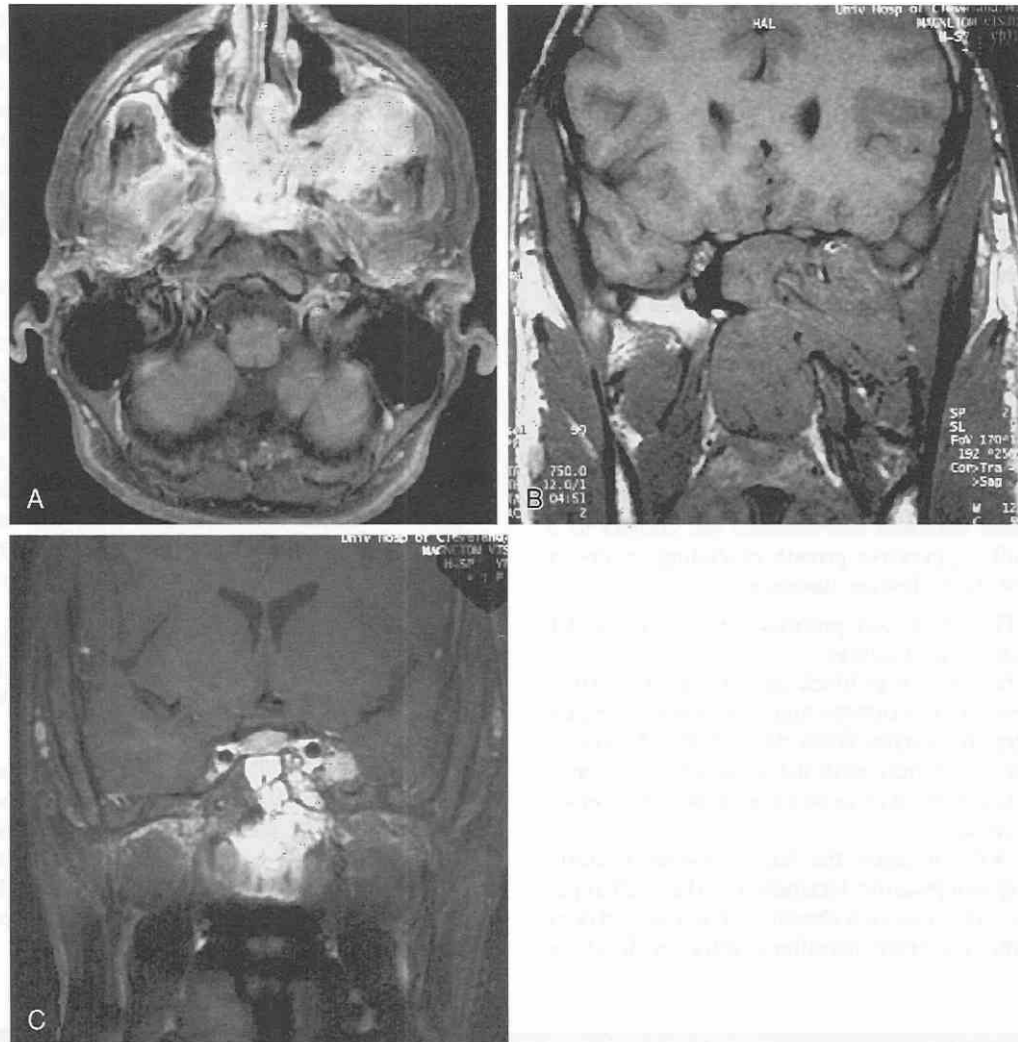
Juvenile nasopharyngeal angiofibroma. MRI scan of a grade 3 angiofibroma in a 15-year-old boy.
